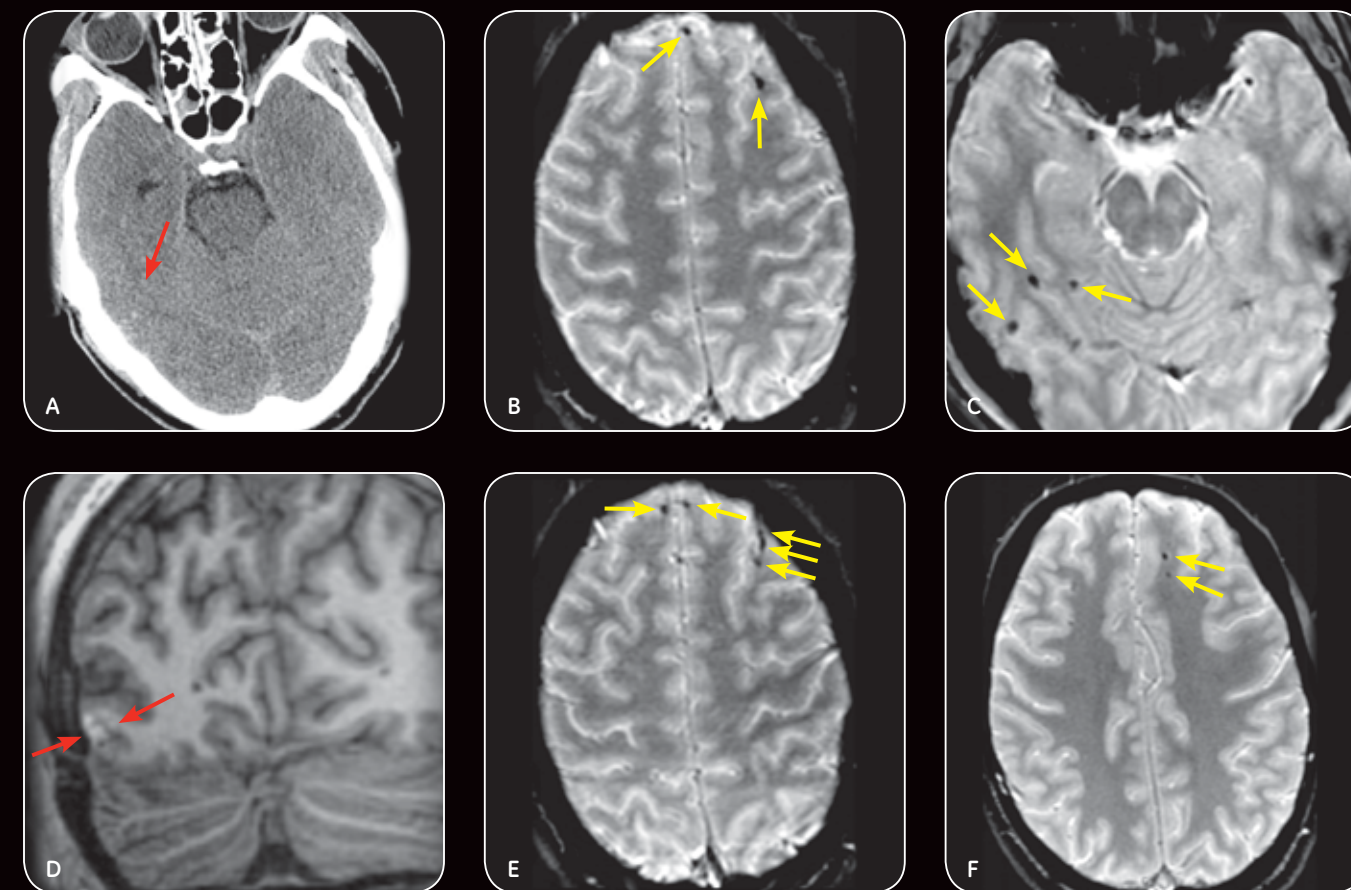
Red arrow in CT (A) demonstrates subtle subarachnoid hemorrhage vs. hemorrhagic contusion in posterior right temporal lobe. 3D T1-weighted fast spoiled gradient echo (FSPGR) MRI (D) demonstrates that this finding represents hemorrhagic contusion (cortical T1 hyperintensity, red arrows) rather than subarachnoid hemorrhage. Yellow arrows in T2*-weighted gradient echo (B,C,E,F) demonstrate innumerable foci of hemorrhage consistent with diffuse axonal injury not detected on CT, even in retrospect.
